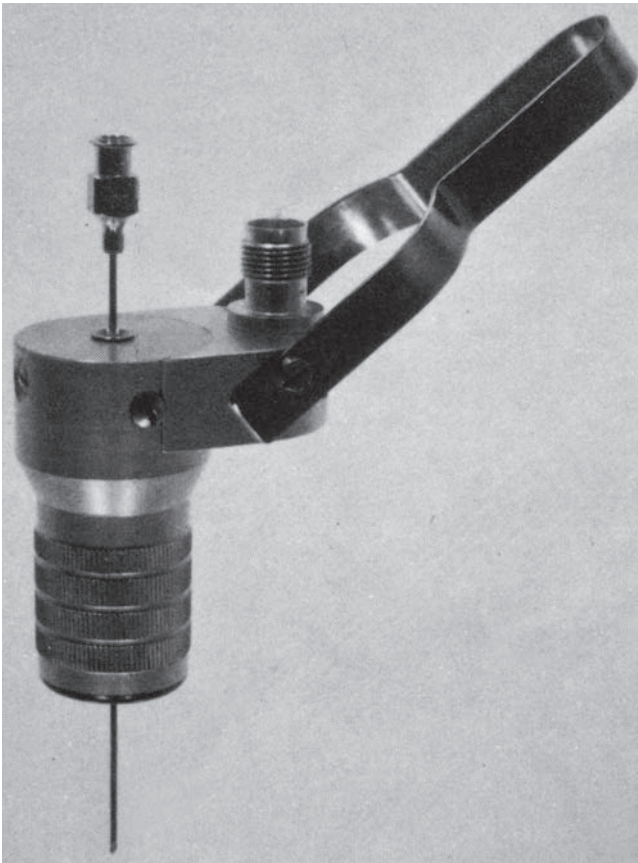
The “central canal” type transducer developed by Holm et al.² Reproduced from Kristensen JK et al., Ultrasonically guided percutaneous puncture of renal masses, Scand J Urol Nephrol 1972; 6(Suppl): 15, 49–56
